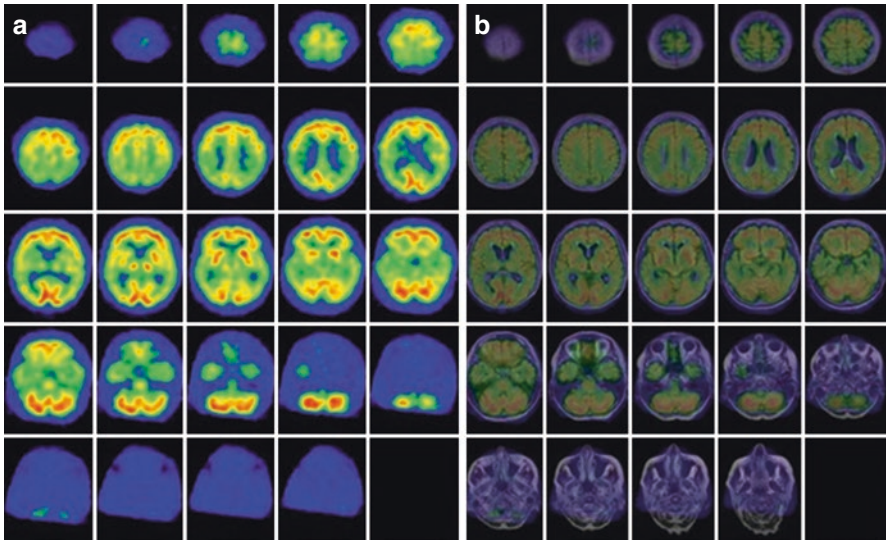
$^{99\text{m}}\text{Tc}$ -HMPAO SPECT derived image of an 81-year-old woman with progressive cognitive decline: (a) axial $^{99\text{m}}\text{Tc}$ -HMPAO SPECT images show severe hypoperfusion in the temporoparietal association cortices and posterior cingulate, with sparing of the occipital cortex, sensorimotor cortex, basal ganglia, thalamus, and cerebellum, consistent with a diagnosis of Alzheimer's disease, (b) Fusion of SPECT with MRI confirms the above findings and demonstrates mild gross cerebral atrophy and white matter changes suggestive of concomitant microvascular disease, a common comorbidity in this population. (From Elman et al. (2014) with permission)
